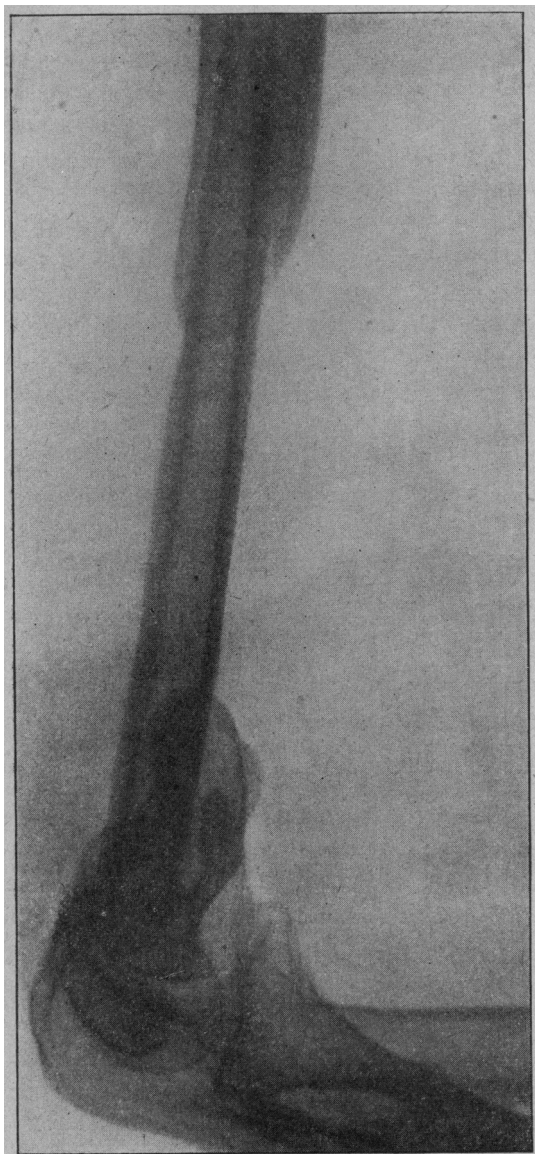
Latest x-ray of graft. Note security of ends of graft.
